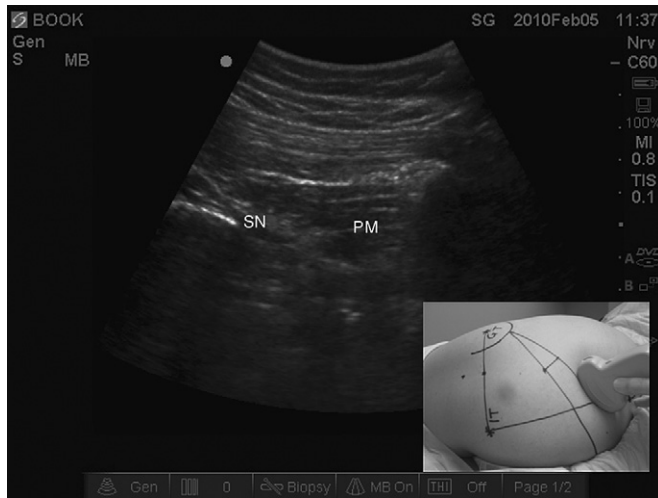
Ultrasonography of parasacral sciatic nerve. SN = sciatic nerve, GMM = gluteus maximus muscle; PM = piriformis muscle. Color Doppler reveals the superior gluteal vessels (SG).
